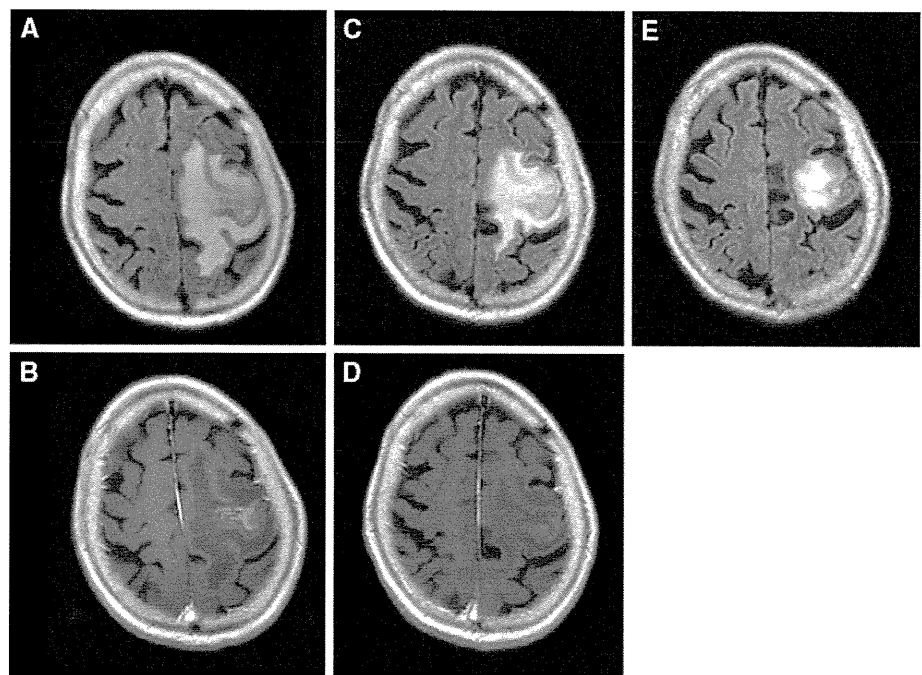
FLAIR MR images before the second treatment with bevacizumab (a) and after 3 cycles of bevacizumab 5 mg/kg (c). Postcontrast T1-weighted MR images before the second treatment with bevacizumab (b) and after 3 cycles of bevacizumab 5 mg/kg (d). *Upper row* an enlarged hyperintense area apparently decreased after the second bevacizumab treatment. *Lower row* postcontrast enhancement became vague after the second bevacizumab treatment
